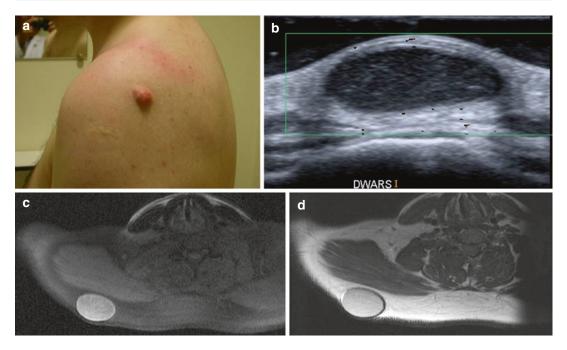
Epidermal inclusion cyst at back of the trunk: (a) clinical image of an epidermoid inclusion cyst on a typical location. (b) ultrasound shows a well-defined hypoechoic ovoid lesion with retroacoustic sound enhancement; (c) axial FS T1-weighted MR image. The
